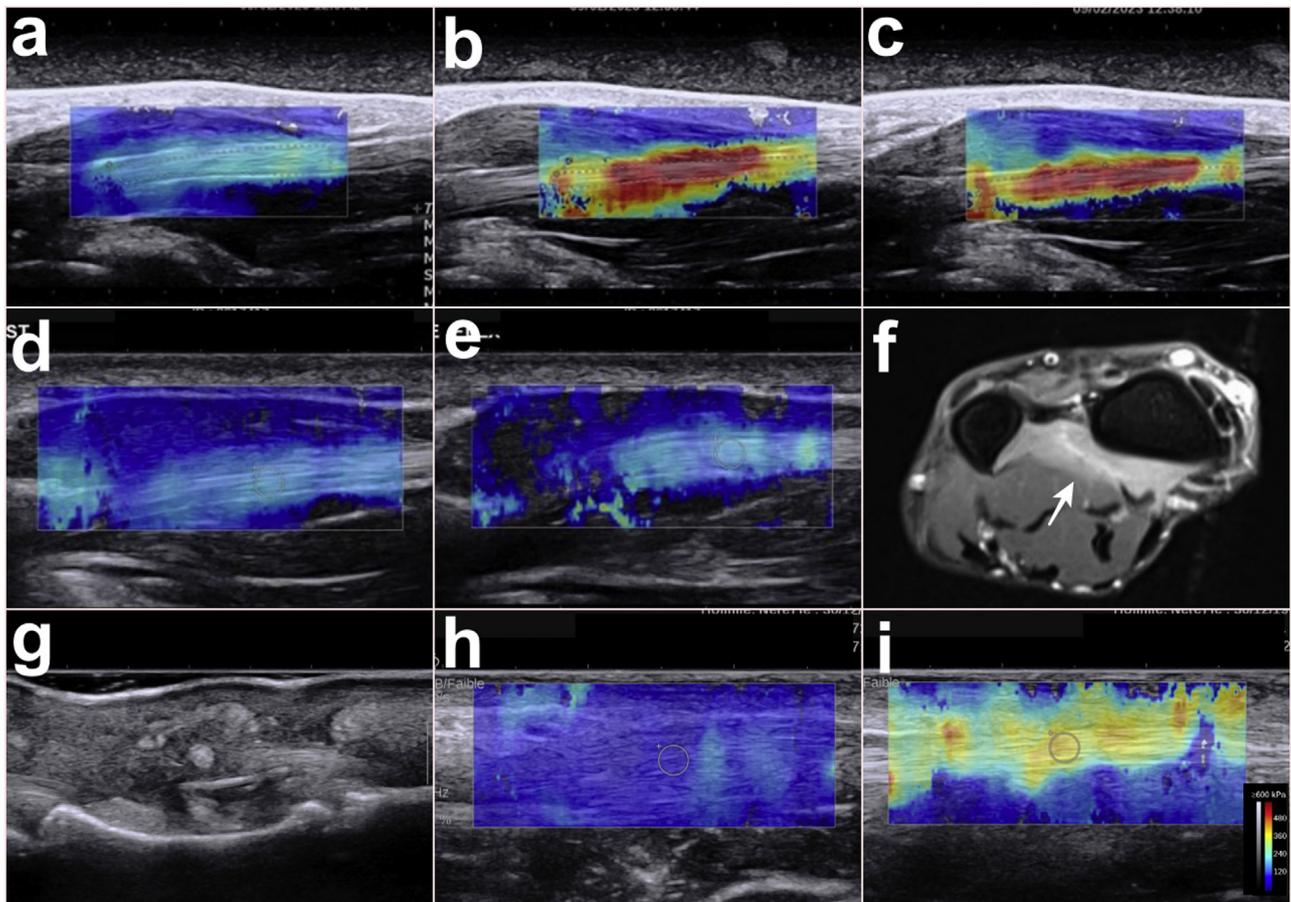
Shear wave elastography of human flexor pollicis longus tendon in physiological conditions at rest (210.1 kPa , $8.4 \text{ m}\cdot\text{s}^{-1}$) (a) and active flexion (490 kPa , $12.7 \text{ m}\cdot\text{s}^{-1}$) (b) and passive extension (486.6 kPa , $12.7 \text{ m}\cdot\text{s}^{-1}$) (c). Patient with anterior interosseous nerve palsy (second row). Shear wave velocity (SWV) and stiffness does not increase between the rest position (175.7 kPa , $7.7 \text{ m}\cdot\text{s}^{-1}$) (d) and active flexion (172.5 kPa , $7.6 \text{ m}\cdot\text{s}^{-1}$) (e). Hyperintensity in flexor pollicis longus and pronator quadratus muscles (arrow) are revealed on 3 T MRI (f). Patient with tendon rupture after repair of the flexor digitorum profundus of the index (third row). Re-tear is difficult to identify in B-mode image (g) proximal to the tear. Stiffness maps show lower values for the flexor digitorum profundus of the index (66.1 kPa , $4.7 \text{ m}\cdot\text{s}^{-1}$) (h) compared to the flexor digitorum superficialis of the index (378.5 kPa , $11.2 \text{ m}\cdot\text{s}^{-1}$) (i).
